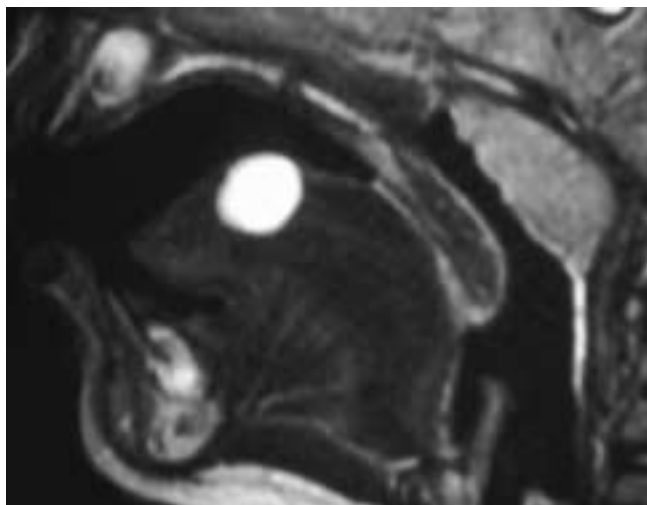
Sagittal T2-weighted MR image shows a cyst in the upper midline tongue of this child. This was a retention cyst.
